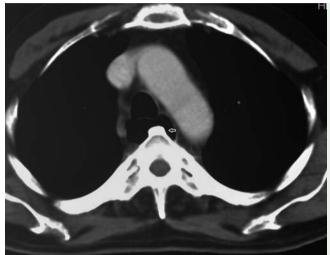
Contrast-enhanced computed tomography showing erosion into the posterior esophageal wall by vertebra (arrow).
